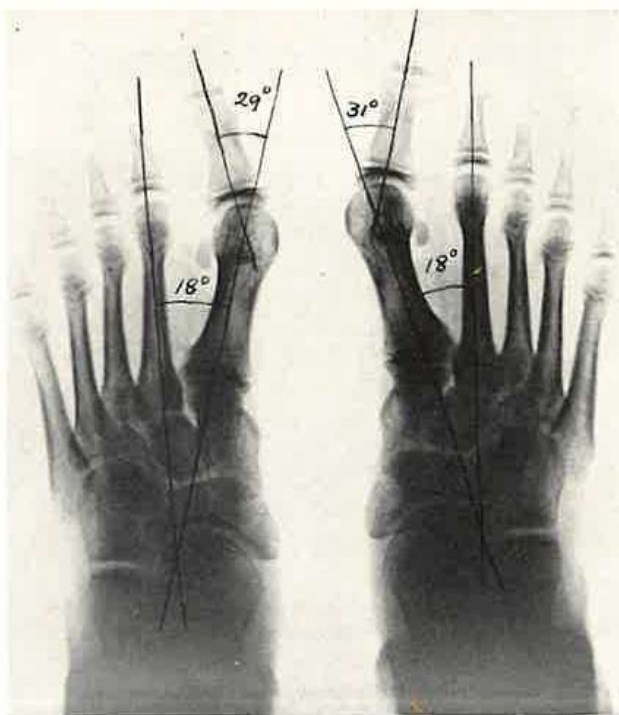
Roentgenogram of feet of a girl 9 years old. Typical atavistic foot with metatarsus varus primus and hallux valgus deformity in spite of the fact that the child had never worn narrow shoes.
